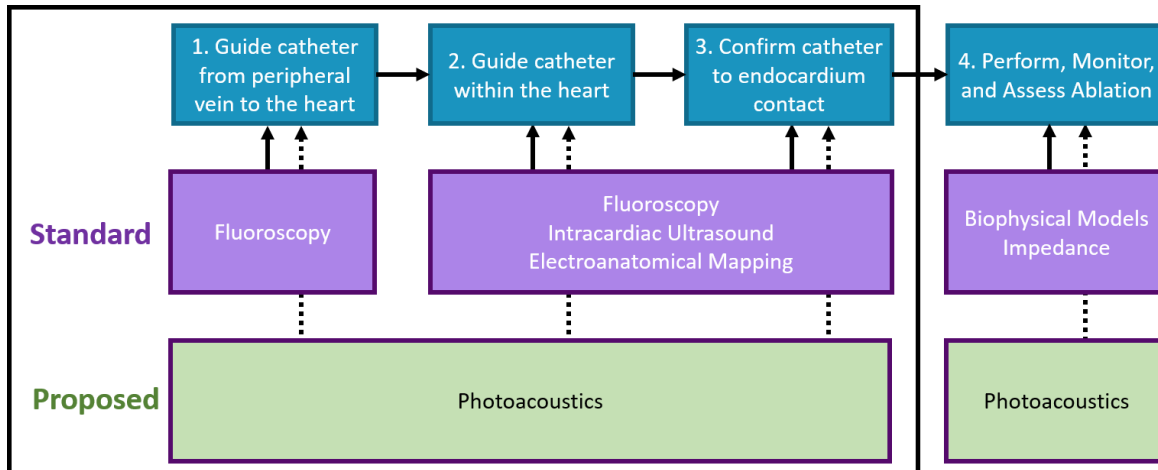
A standard cardiac catheter interventional procedure relies on fluoroscopy, electroanatomical mapping, intracardiac echocardiography, biophysical models, and impedance measurements for successful implementation. We are proposing to replace (or significantly mitigate) fluoroscopy by introducing photoacoustic image guidance across each of the four stages of the standard procedure. The black box indicates the stages of the procedure addressed by our robotic-photoacoustic system.
